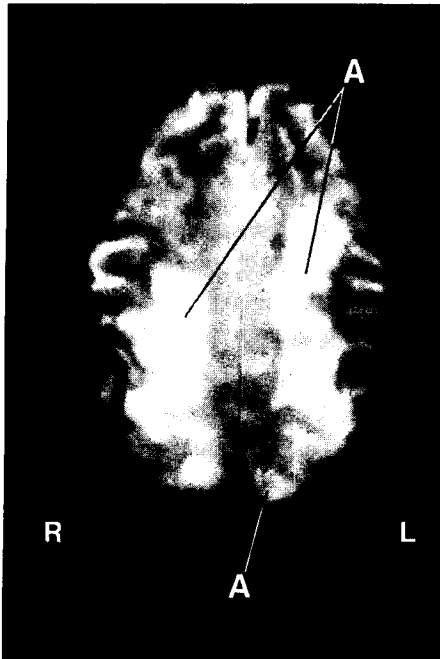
MRI (T_2 weighted) cut of the brain of RJ 2 d post air embolism. Areas of long T_2 appear lighter (A), indicating localized increased brain water content.
